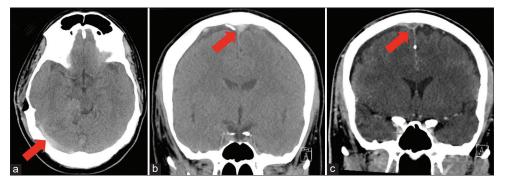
(a) Axial noncontrast computed tomography (CT) demonstrating a hyperdense right transverse sinus (arrow). (b) Coronal noncontrast CT demonstrating a hyperdense superior sagittal sinus (SSS) (arrow). (c) Coronal CT venogram demonstrating thrombosis of the SSS (arrow).
